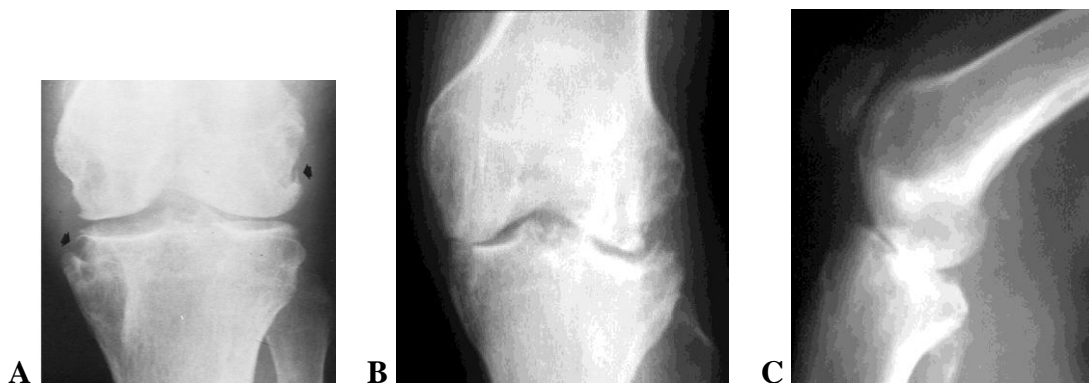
Radiographs region of knee. (A) Tuberculous arthritis of the knee. On both sides of the joint there are destructive bone lesions (arrows) involving the medial and lateral condyles and the medial aspect of the proximal tibia. Note the relative sparing of the articular cartilage and preservation of the joint space in view of the degree of bone destruction. (B, C) Different patient with two views, tuberculous arthritis of the knee.
